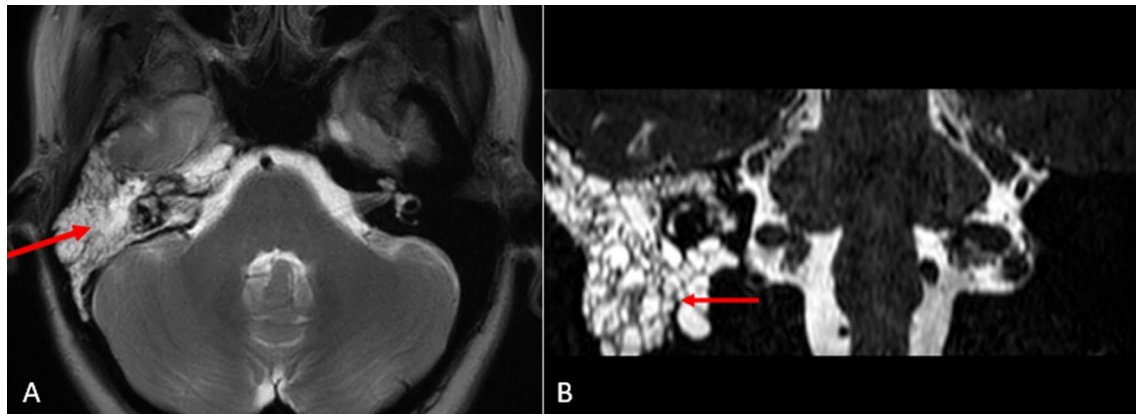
A T2W axial section showing T2 hyperintensity within the right mastoid air cells (red arrow) and middle ear cavity. It is further seen extending to involve the hyper-pneumatized right petrous body. B MRI CISS coronal section showing the T2 hyperintensity within the right mastoid air cells (red arrow)
